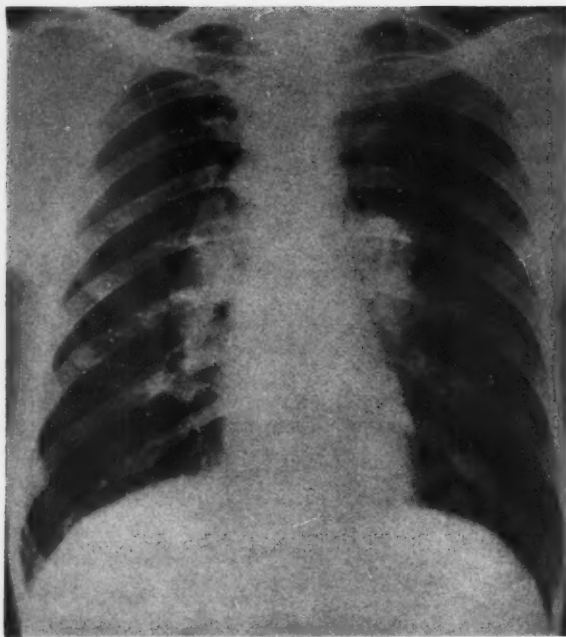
Case 1. X-ray of chest revealing bilateral hilar adenopathy.
